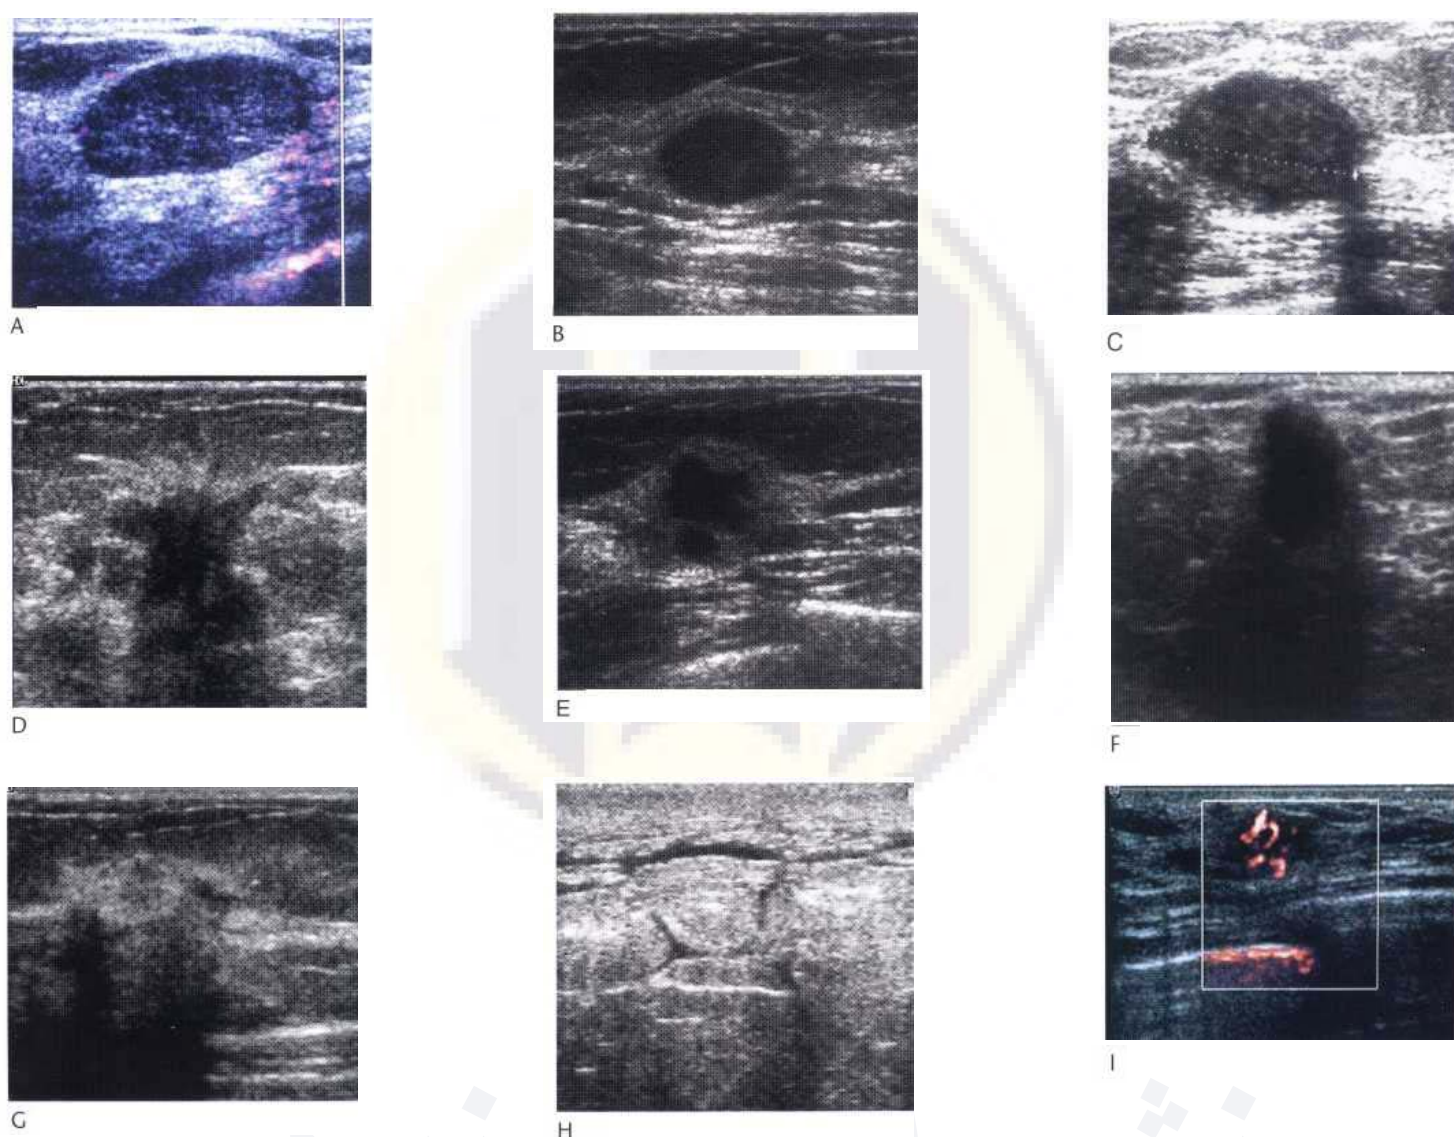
(A). A typical fibroadenoma with homogeneous internal echoes with an ovoid shape and circumscribed margins. There is posterior acoustic enhancement. (B,C) Examples of malignant breast masses with 'benign' ultrasound characteristics. The medullary carcinoma in B has a smooth well-defined margin and is 'wider than tall'. The grade 3 invasive ductal carcinoma in C has marked posterior acoustic enhancement; however its margins are irregular and microlobulated. (D) A typical 'tall' irregular spiculated hypoechoic attenuating mass in keeping with a malignant breast tumour. (E,F) Two examples of fat necrosis mimicking malignant lesions. The case in E shows two hypoechoic areas with irregular outlines. The case in F shows a 'tall' hypoechoic lesion with posterior acoustic shadowing. (G) An invasive lobular carcinoma presenting as areas of scattered indeterminate attenuation. There is also increased hyperechogenicity of intramammary fat on the right side. (H) Inflammatory breast cancer with secondary signs. Note the loss of the normal glandular adipose differentiation due to increased hyperechogenicity of the intramammary fat. Lymphatic dilatation is also apparent under the thickened subcutaneous layer. (I) A power Doppler image of an invasive grade 3 breast cancer. Note the high density of irregular tortuous and branching vessels penetrating into the centre of the tumour.
